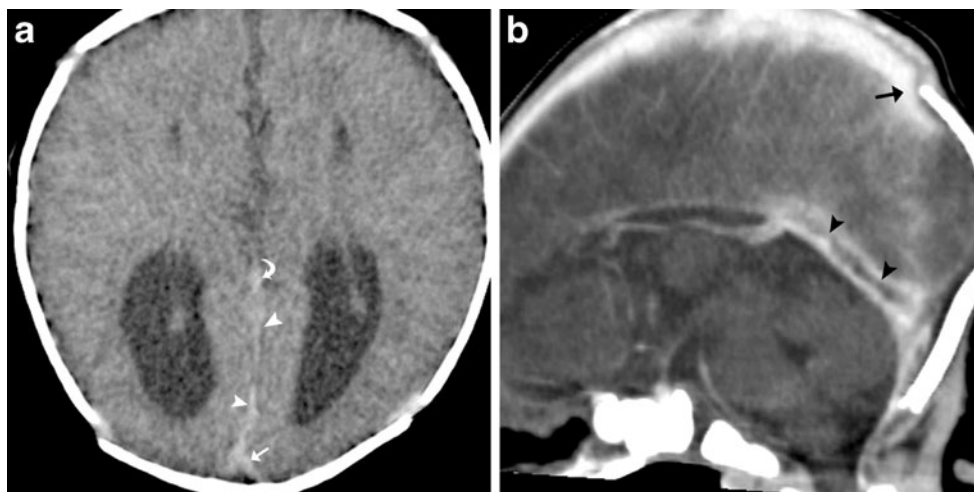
Sinovenous thrombosis: value of CT venography. Images in a newborn known to have agenesis of the corpus callosum who presented with seizures. a Axial unenhanced CT shows increased attenuation within the great cerebral vein or vein of Galen (*curved arrow*), straight sinus (*arrowheads*) and torcular Herophili (*arrow*). b Sagittal
